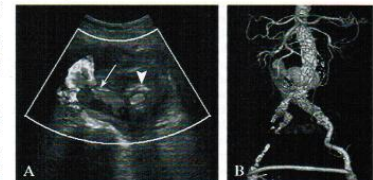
One week DUS (A) and CTA (B) confirming patent stent-graft (arrow-head) and persistent ACF (arrow).
